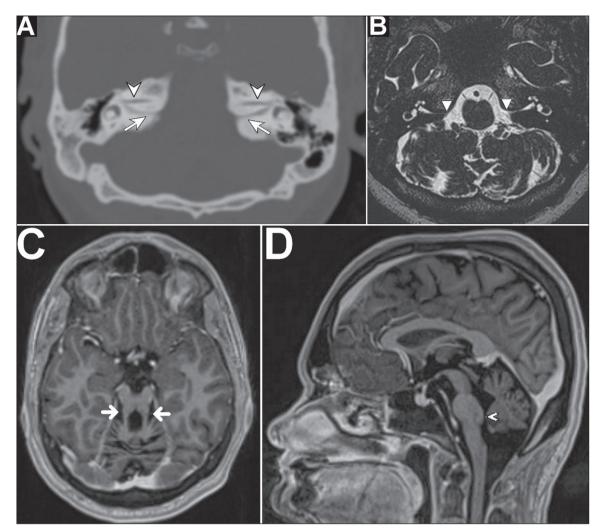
A: Oblique axial CT scan of the ears, with bone window settings, showing a narrow, duplicated internal auditory channel, one channel containing the facial nerve (arrowhead) and the other containing the vestibulocochlear nerve (arrow). B: Axial T2-weighted MRI scan of the brain and ears, revealing the absence of the eighth cranial nerve (arrowhead). C: Oblique axial T1-weighted, volumetric, intravenous contrast-enhanced MRI of the brain and ears, showing elongated, discretely lateralized superior cerebellar peduncles (arrows), similar in appearance to the molar tooth sign. D: Sagittal T1-weighted, volumetric, intravenous contrast-enhanced MRI of the brain and ears, showing cerebellar hypoplasia with a dysplastic aspect and with a reduction in the volume of the pons, especially in its ventral aspect, presenting a small prominence on the posterior surface projecting into the fourth ventricle (arrowhead).
